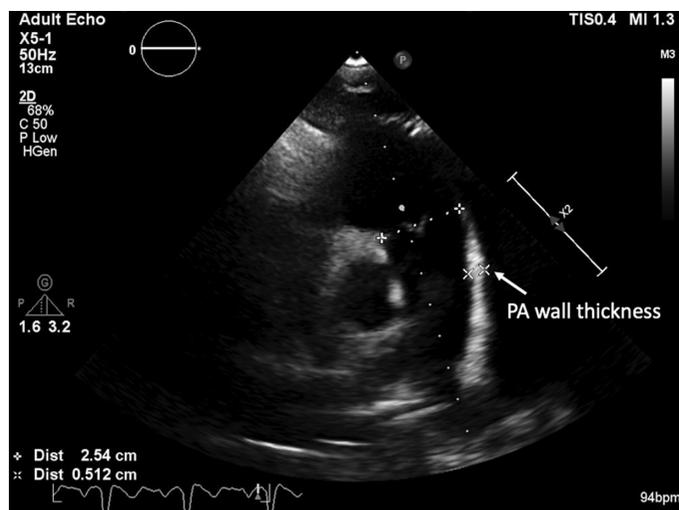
Measurement of pulmonary artery wall thickness in parasternal short axis view at the level of aortic valve.
